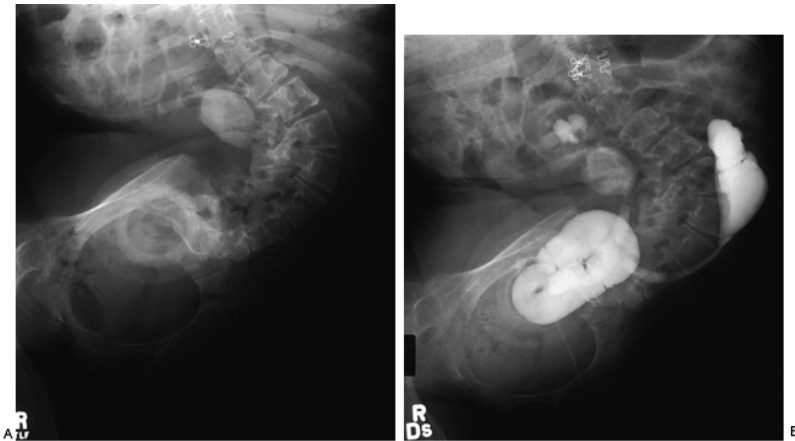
A: Plain film in this myelodysplasia patient status post-urinary diversion reveals a large calcification filling the right upper quadrant. B: Loopogram reveals free reflux into a nonfunctioning shell of a left kidney and hydronephrosis on the right associated with the large renal pelvic calculus. Percutaneous access to this stone is hindered by the severe scoliosis and would require supracostal puncture with risk of injury to the pleura or liver on the right. Open pyelolithotomy was indicated with consideration for simultaneous left nephrectomy.
